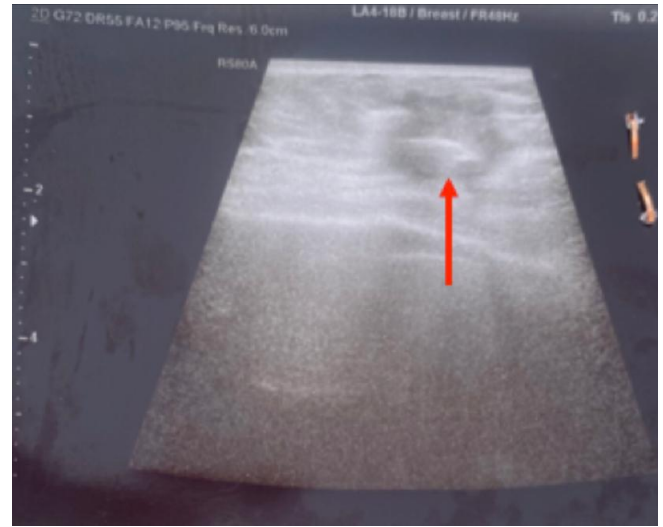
Shows the Ultrasound image of left-side breast cancer mass
